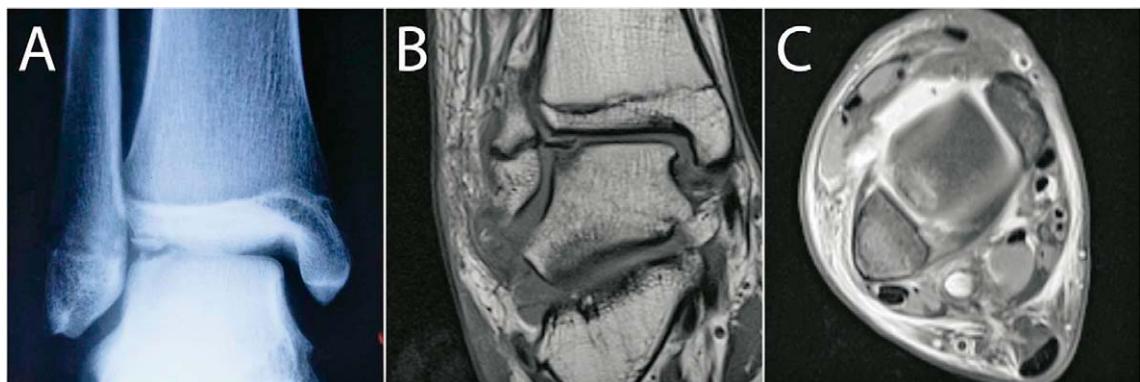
Preoperative plain radiograph and magnetic resonance imaging scans of the right ankle in patient 1: (A) plain radiograph in the anteroposterior view shows displaced osteochondral fragment in the anterolateral part of the right talus; (B) coronal spin echo T1 image shows lateral inverted osteochondral fracture of the talus (LIFT) on the anterolateral part of the right talus. There is inversion of the subchondral-bone plate crescent, reversal of the subchondral-cancellous bone layers and the presence of a radiolucent gap beneath the fragment; (C) axial fat saturated proton-density turbo spin echo weighted image shows osteochondral lesion of the anterolateral part of the right talus surrounded with bone marrow edema.
